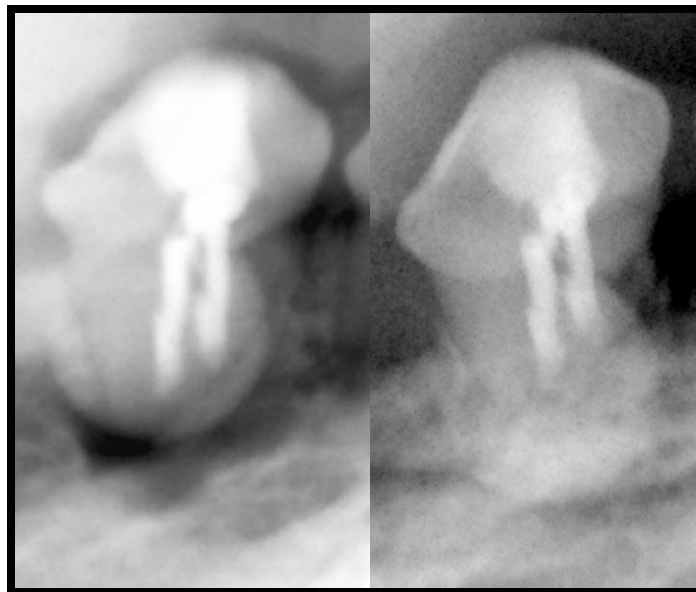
“IRM tooth” radiographs post-surgical vs. 6 month follow-up 2
